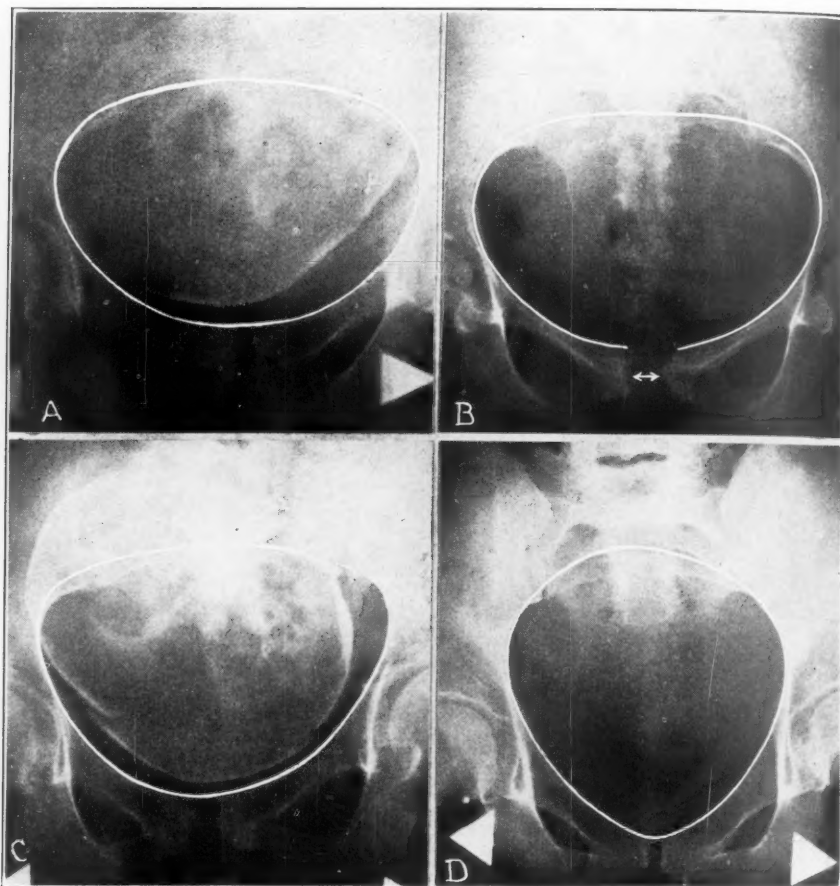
Pelvic type and mechanism of delivery in relation to stillbirth.* A, X-ray No. 90557. Chart No. 309025. The pelvis conforms to the typical flat android type. Arrest occurred in midpelvis in the transverse position. The child was seriously injured by forceful attempts at anterior rotation with a poor cephalic application to the oblique anterior position. This type of pelvis favors the transverse mechanism described in Fig. 5. Weight of stillborn child, 3760 gm. The second child was delivered spontaneously, 4020 gm.
